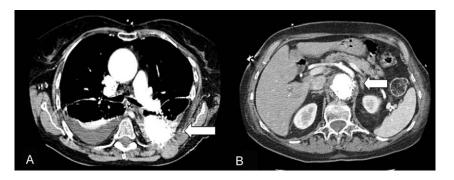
Postoperative computed tomographic scan reveals (A) successful thoracic aortic stent-graft exclusion of pseudoaneurysm, and (B) successful exclusion of true aneurysm at the level just proximal to the celiac axis.
